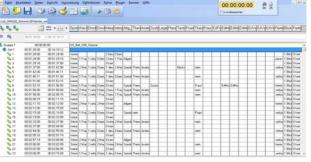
Future parents' triadic capacity ("Tc\_sono20", screen-shot): a standardized setting to measure parental attitudes to pregnancy while watching a non-diagnostic ultrasound
